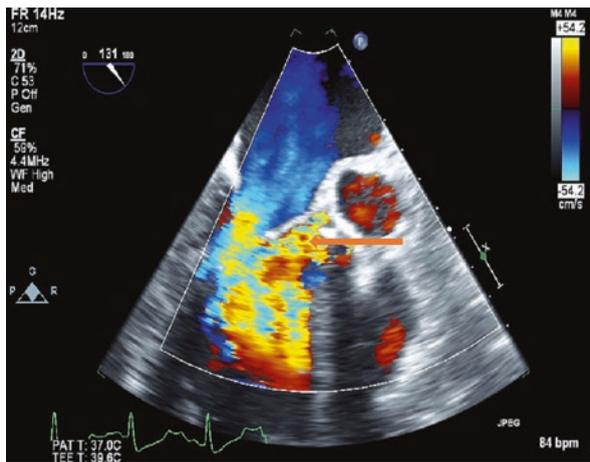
Mid-esophageal long axis view with color Doppler in a patient with aortic valve endocarditis showing severe regurgitation at the aortic valve
